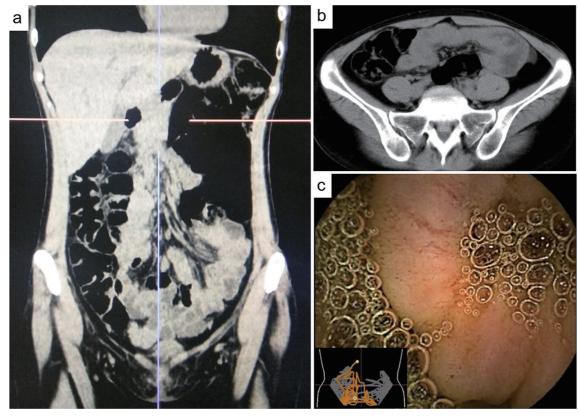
Findings on non-contrast abdominal CT and small intestinal mucosa on capsule endoscopy.
